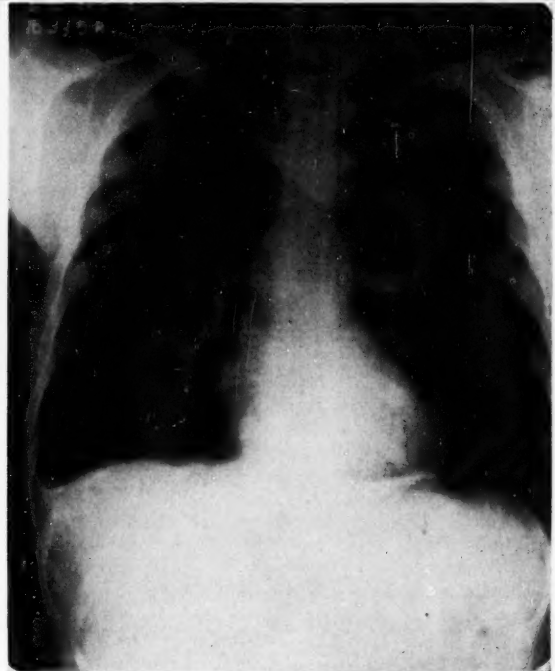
Chest x-ray of Case 3 (E. L. S.) during convalescence showing obliteration of the right costophrenic sinus with complete clearing of pulmonary involvement.
